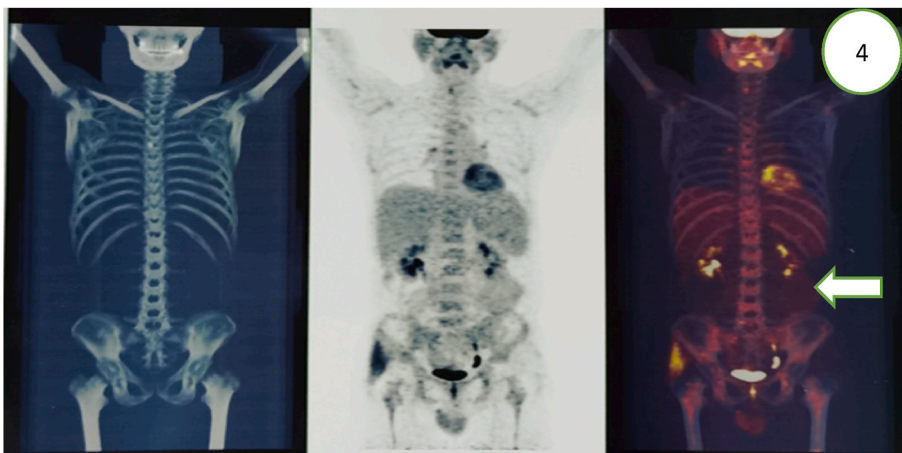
PET-CT examination showed that the spleen was not large, metabolism was not high, and tumor activity was inhibited.
